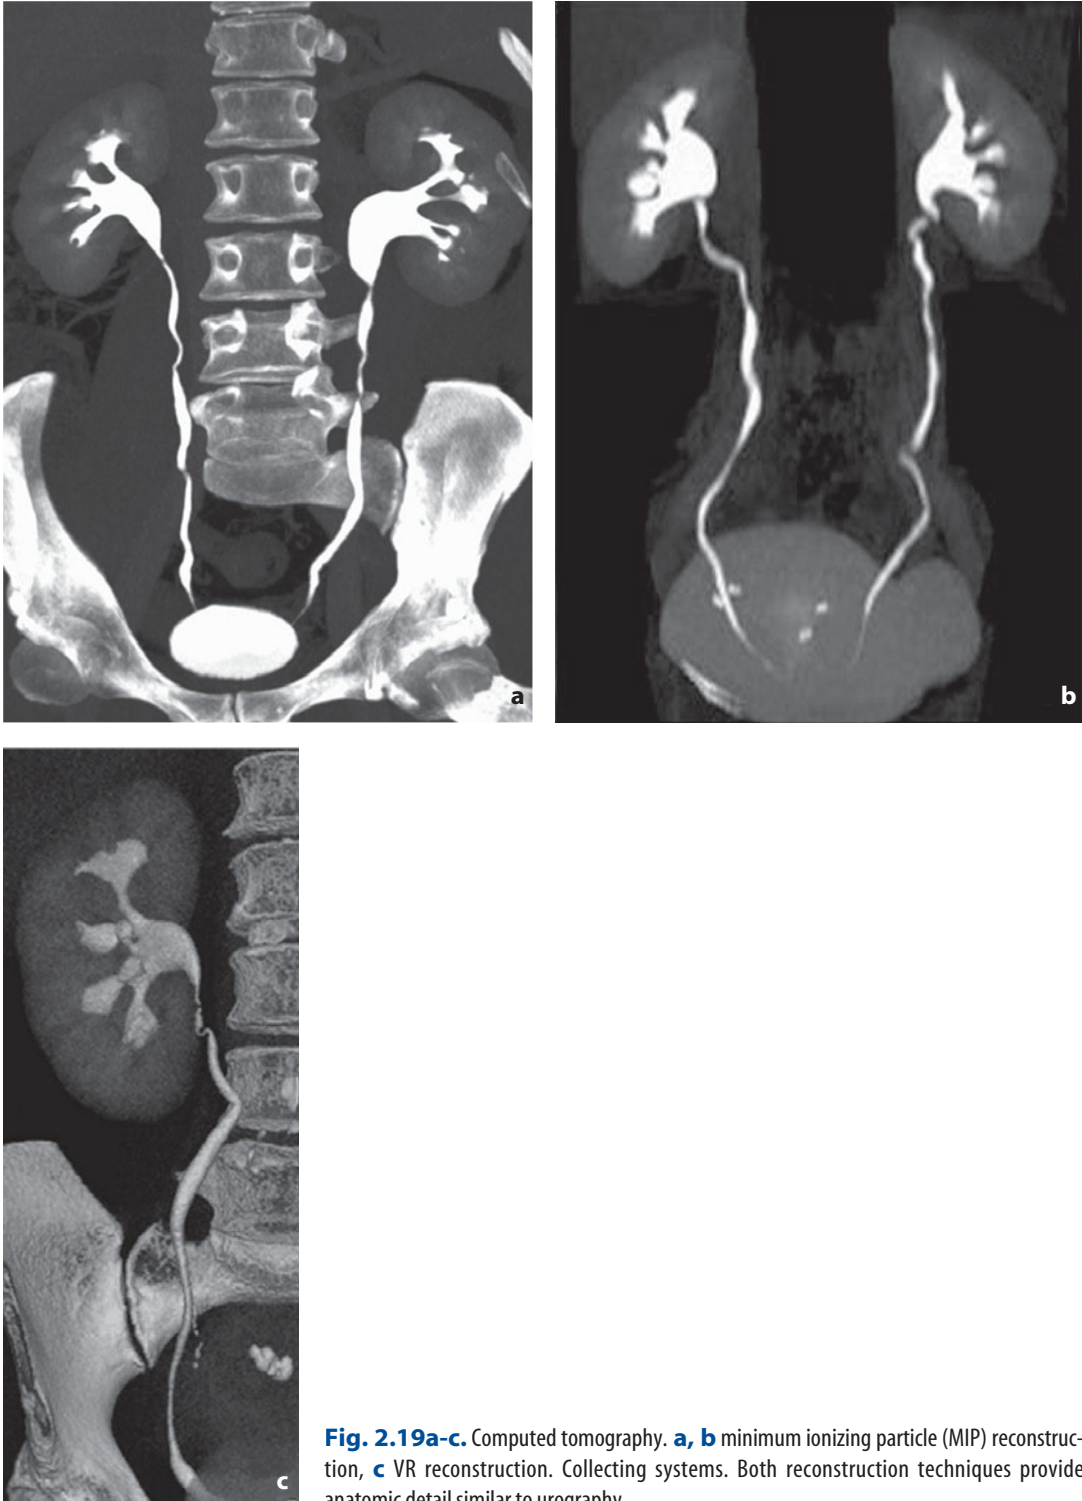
Computed tomography. a, b minimum ionizing particle (MIP) reconstruction, c VR reconstruction. Collecting systems. Both reconstruction techniques provide anatomic detail similar to urography
